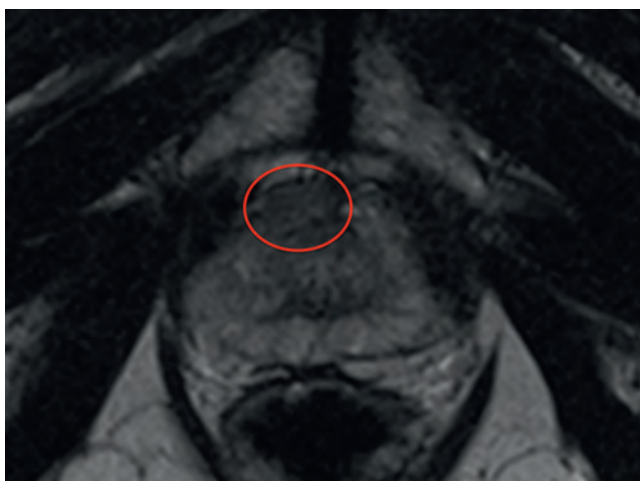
A 66-year-old man with a prostate-specific antigen level of 7.5 and normal rectal examination findings underwent prebiopsy magnetic resonance imaging (MRI) as part of a validating cohort trial called the Prostate MRI Imaging Study (PROMIS). This involves prebiopsy MRI that remains blind to the physician and the patient. The patient then undergoes a transrectal biopsy and a template mapping transperineal biopsy at a sampling frame of 5 mm. This image shows a discrete lesion anteriorly on T2-weighted MRI.
